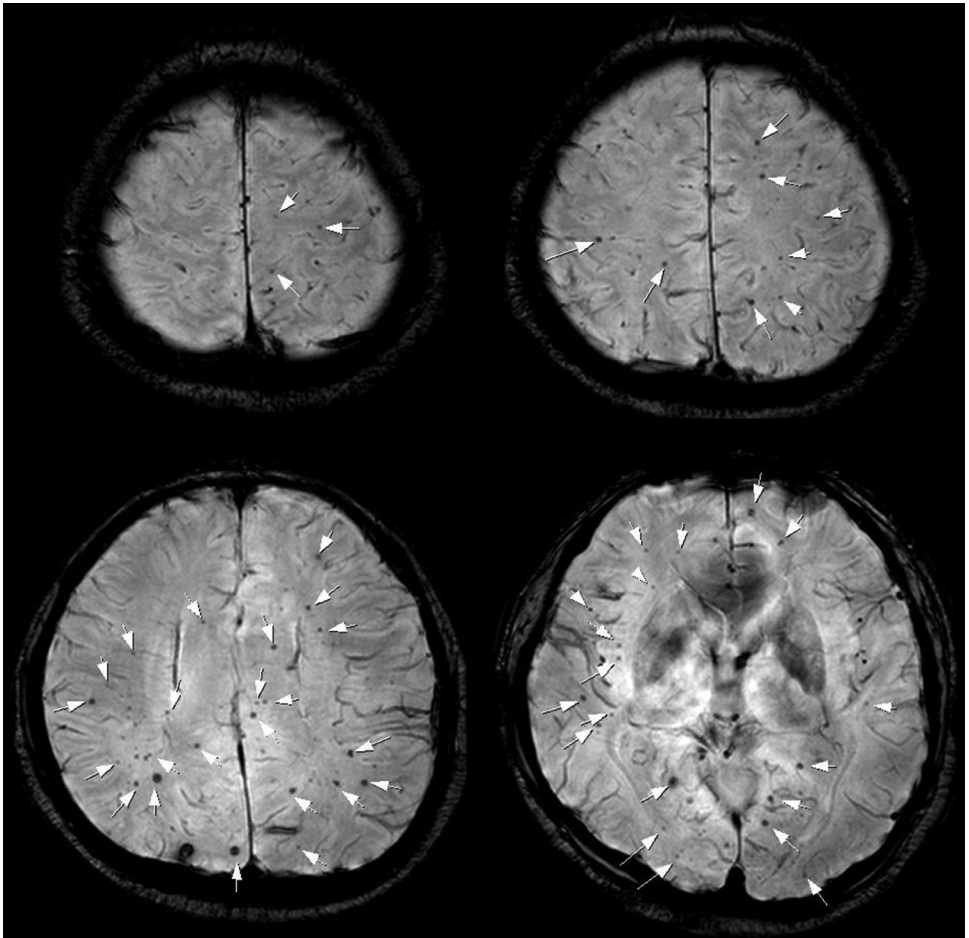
Susceptibility-weighted brain magnetic resonance imaging showed numerous old microbleeds in the bilateral cerebrum and cerebellum, suggestive of radiation-induced cavernous malformation.
